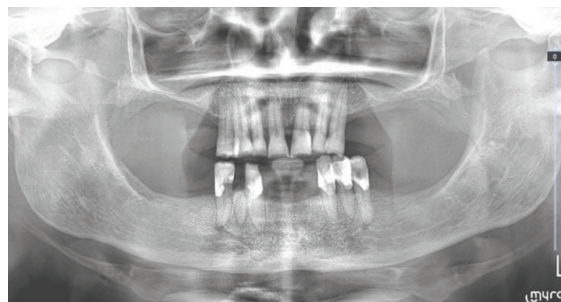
Orthopantomography that shows the condition of the jaw bones and residual elements.
